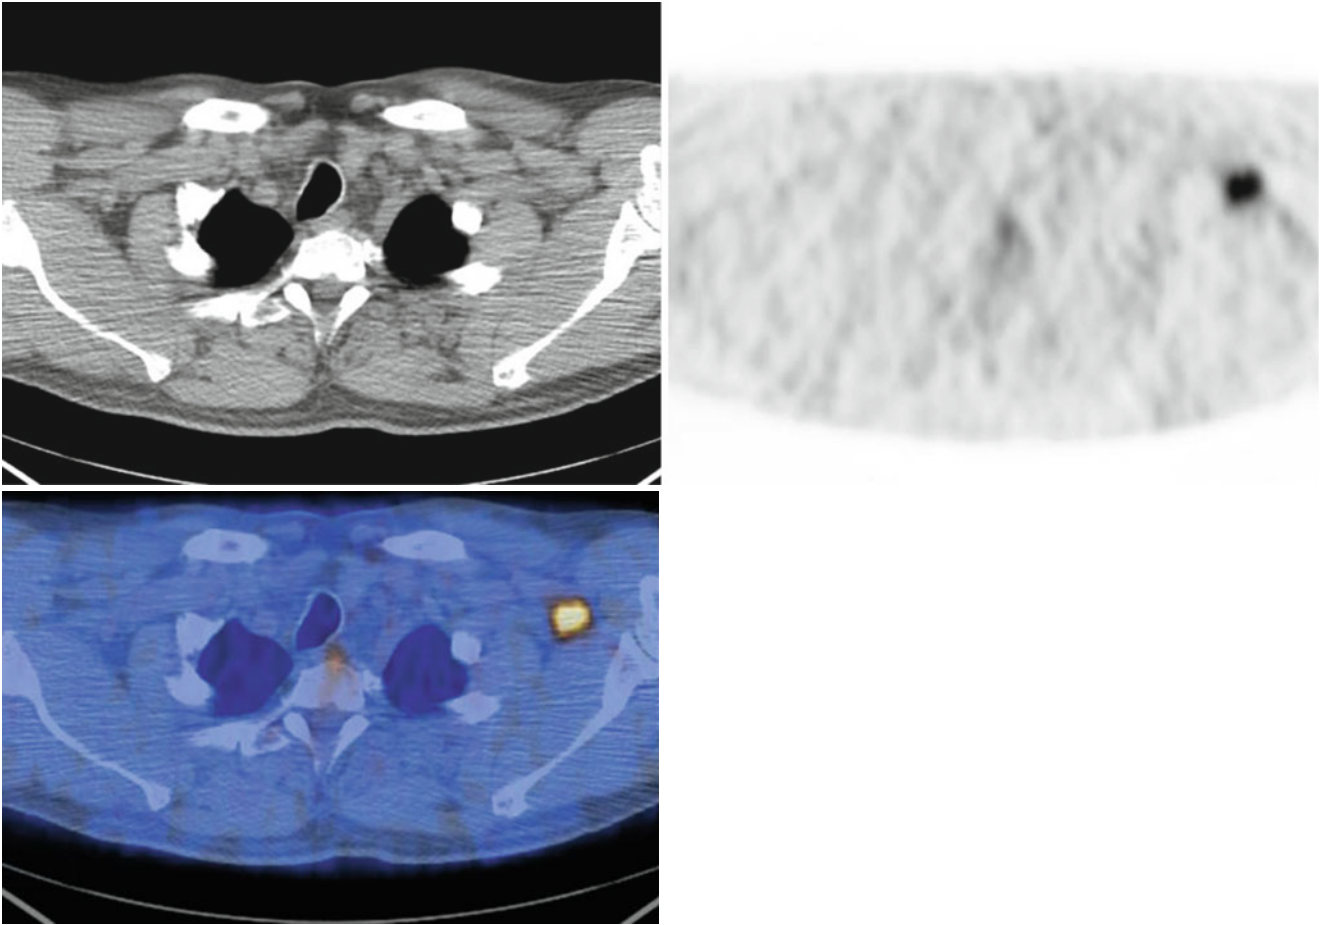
PET scan highlighting a left axillary lymph node that was missed on the conventional CT (*above*) in a patient with lymphoma (Courtesy of Dr Tom Lynch)
